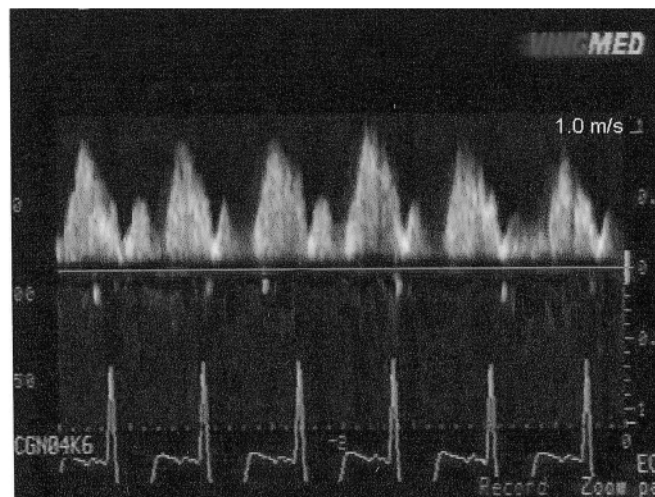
Doppler analysis of flow in the distal left anterior descending coronary artery after aortic valve replacement: (A) at rest and (B) during hyperemia. Note the forward systolic flow, the reduced resting peak diastolic velocity and the increased hyperemic peak diastolic velocity.
